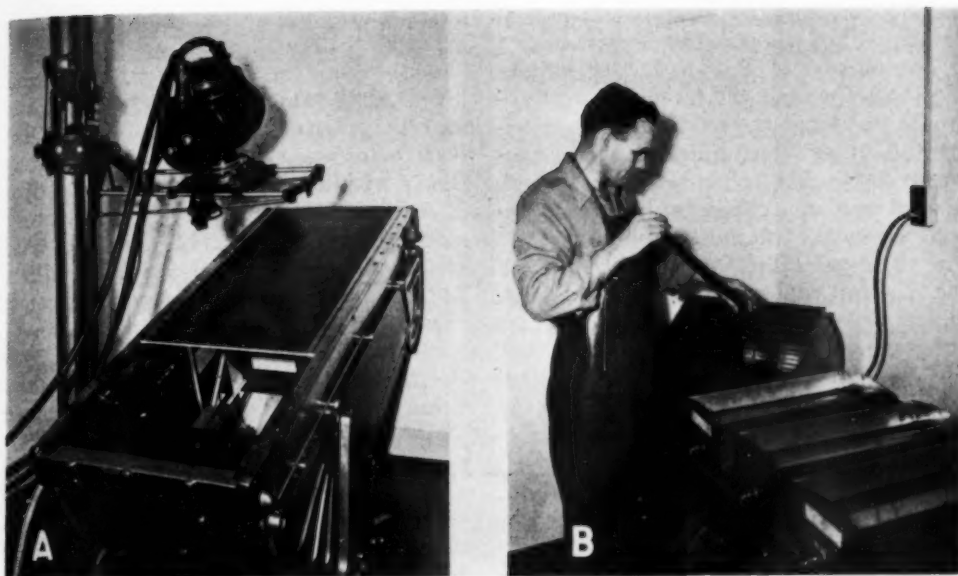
A. Cinefluorographic equipment has been installed in a motor-driven, tilting x-ray table. The 35-mm. camera is directed toward a front surfaced mirror, supported at  $45^\circ$  by a metal frame. A fluorescent screen, mounted just beneath the table top on this frame, can be seen in the reflection from the mirror.
